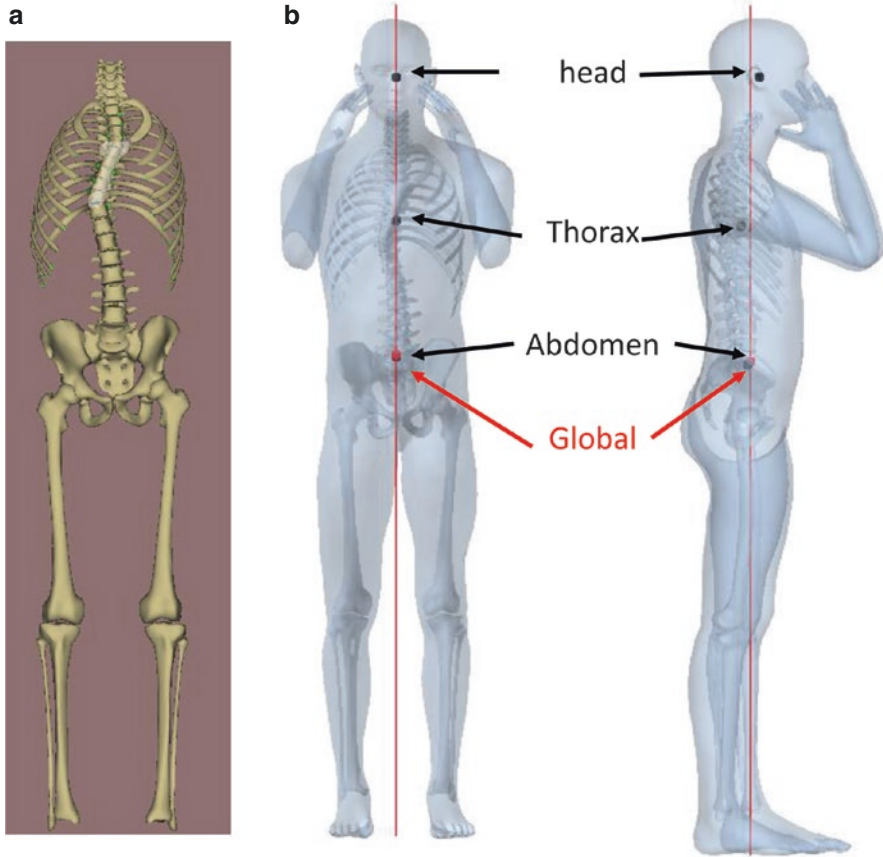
From the biplanar X-rays, (a) longitudinal skeleton, (b) 3D reconstruction of the external envelope and barycentremetry allowing estimation of the gravity line, passing through the global center of mass of the subject. Center of mass of various body segments, such as the head, thorax, or abdomen, can be computed
